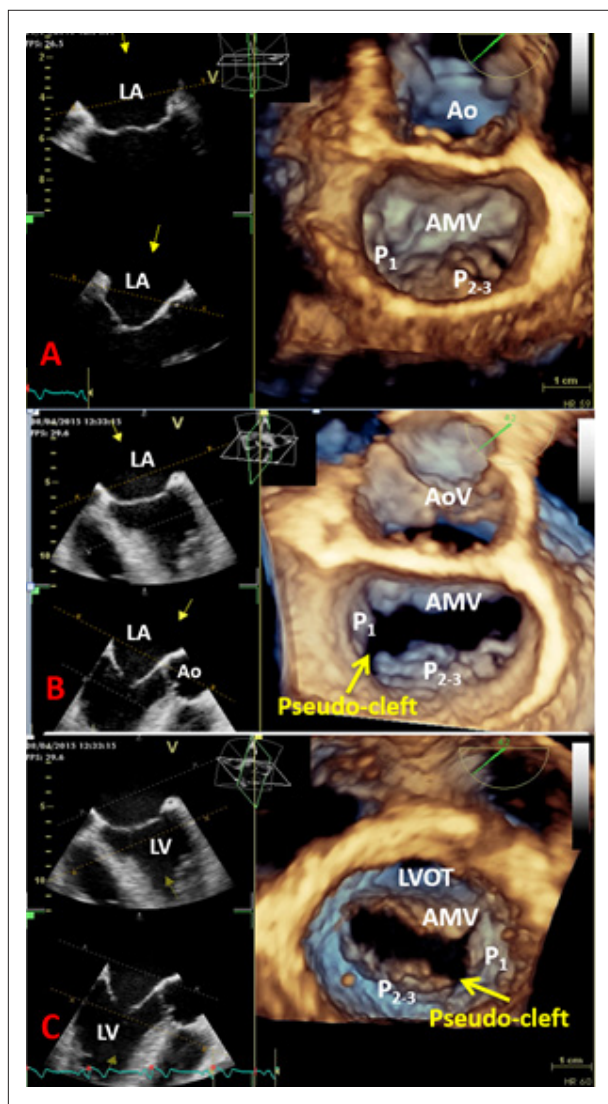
Three-dimensional morphological assessment of the mitral valve (transesophageal approach). Panel A. "Surgical view" of the closed mitral valve, seen from the left atrial side, which shows a complex prolapse of the P2-3 scallops. The anterior mitral valve leaflet shows normal morphology. Panel B. Opening of the mitral valve reveals that the P1 segment is separated from the P2-3 segments, raising the suspicion of a pseudo-cleft. Panel C. The mitral valve visualized from the left ventricular side. The pseudo-cleft of the posterior mitral valve leaflet, between the P1 and the P2-3 segments, can be identified. AMV: anterior mitral valve; Ao: aorta; AoV: aortic valve; LA: left atrium; LV: left ventricle; LVOT: left ventricular outflow tract.
